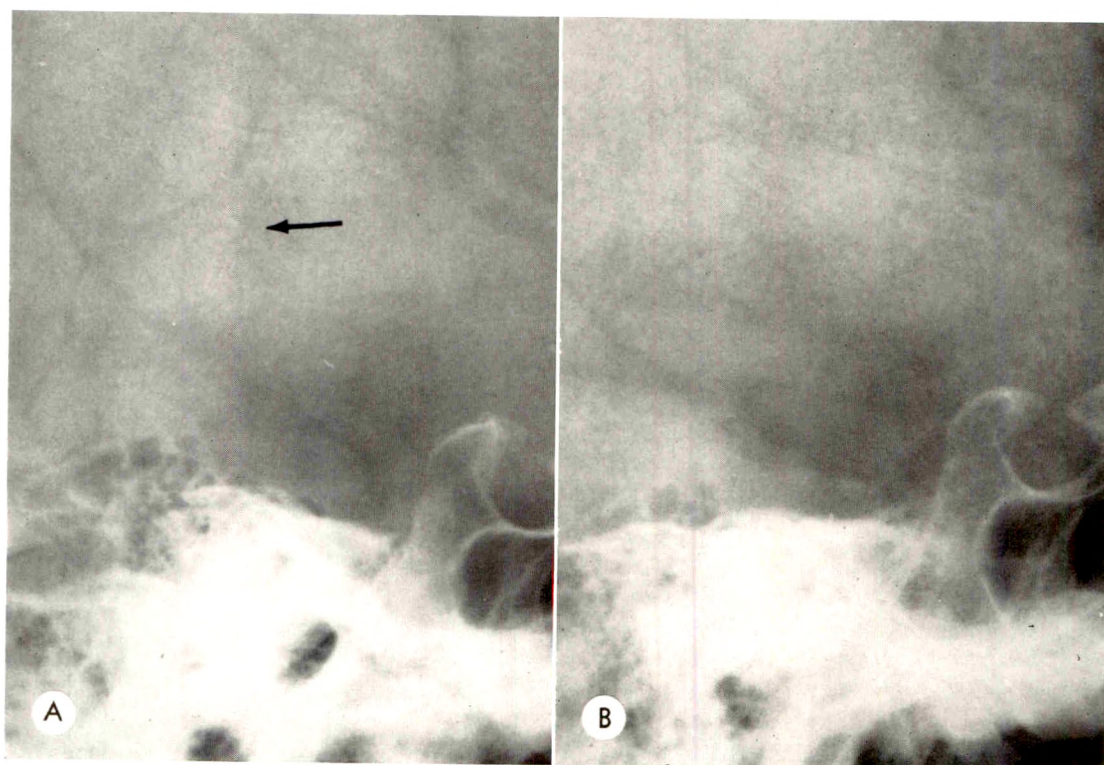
(*A* and *B*) Stereoscopic lateral skull roentgenograms showing the habenular calcification on only one of the stereo pair.
